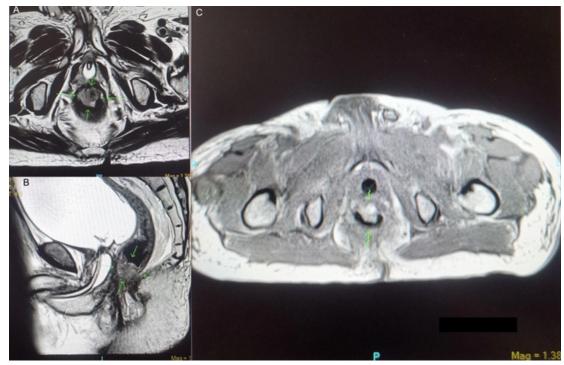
Whole abdominal MRI with contrast four months post surgery revealed (A) on axial view, an increase in size of the previously seen anterior low rectal mass measuring $2.3 \times 2.7 \times 1.8$ cm. (previously $1.3 \times 1.9 \times 1.4$ cm.) and increase in size of the partially exophytic left low to mid rectal mass, measuring $4.0 \times 3.4 \times 3.4$ cm. (previously $2.4 \times 1.8 \times 1.8$ cm); (B) on sagittal view; (C) A rim-enhancing T2 hyperintense perianal signal abnormality with marked restricted diffusion measuring $2.0 \times 0.9 \times 2.6$ cm., involving the anal mucosa at 7 o'clock and extending to the anal verge, probably a new perianal abscess
